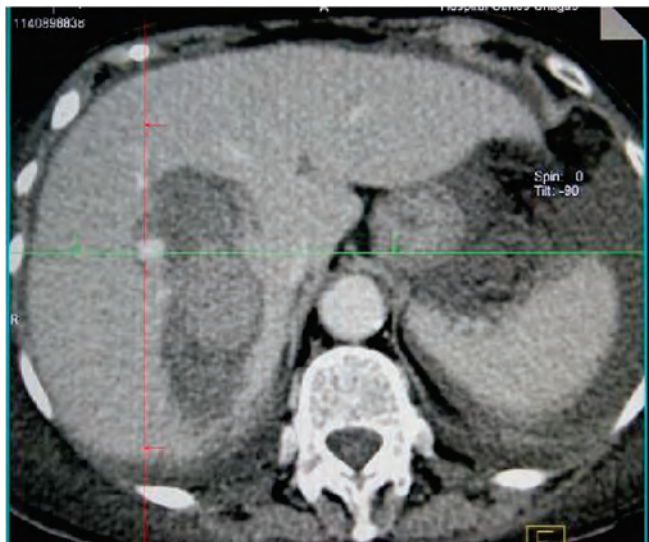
CT: section showing abundant hemoperitoneum.
